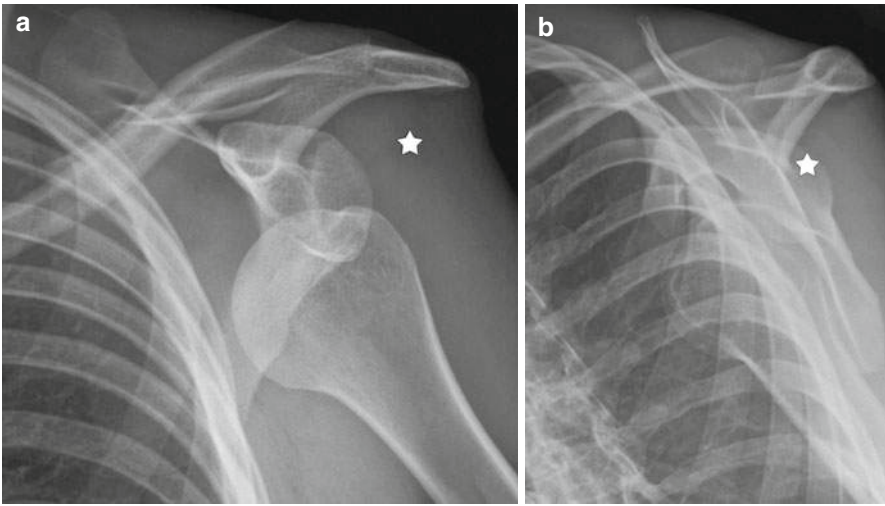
Anterior dislocation. Shoulder X-ray anteroposterior (a) and scapular Y (b) views reveal inferior and anterior dislocation of the humeral head from its expected location (*star*)
